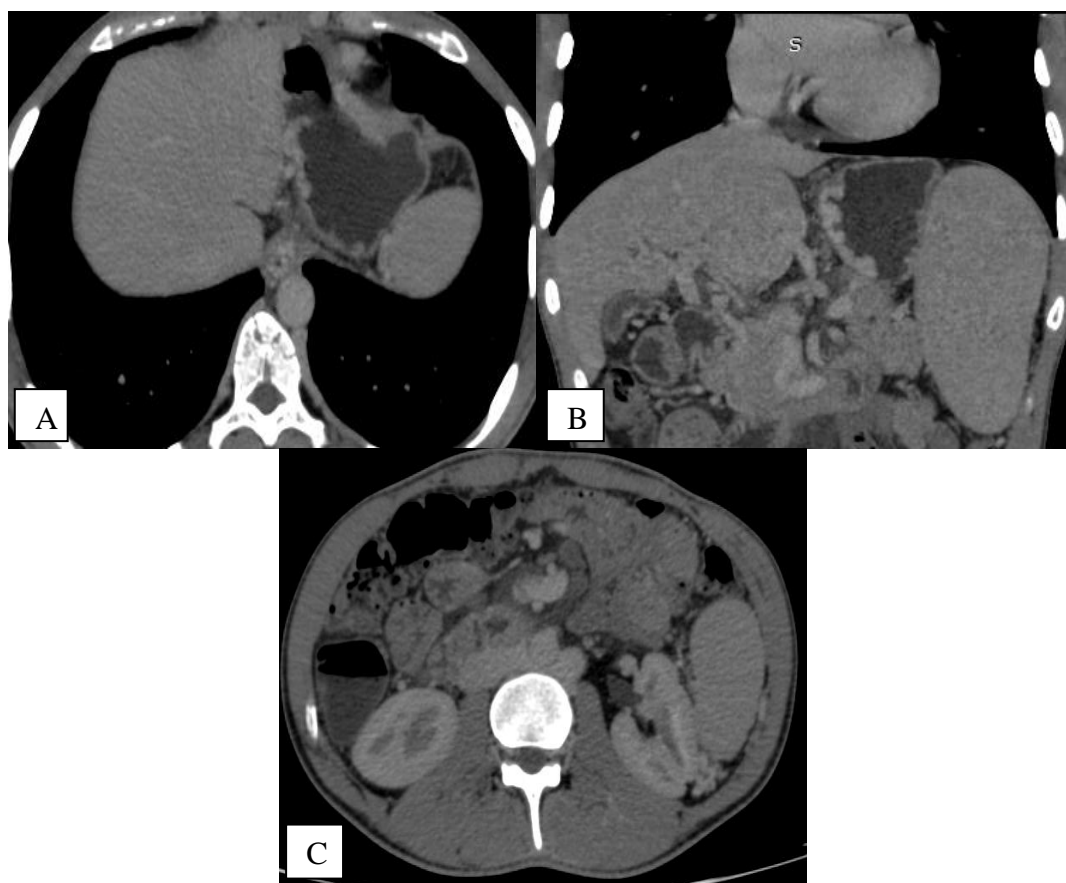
Multidetector computed tomography with contrast enhanced axial and reformed coronal images showing few esophagogastric collaterals, some of them protruding intraluminally, outflow being left renal vein which has retroaortic course.
